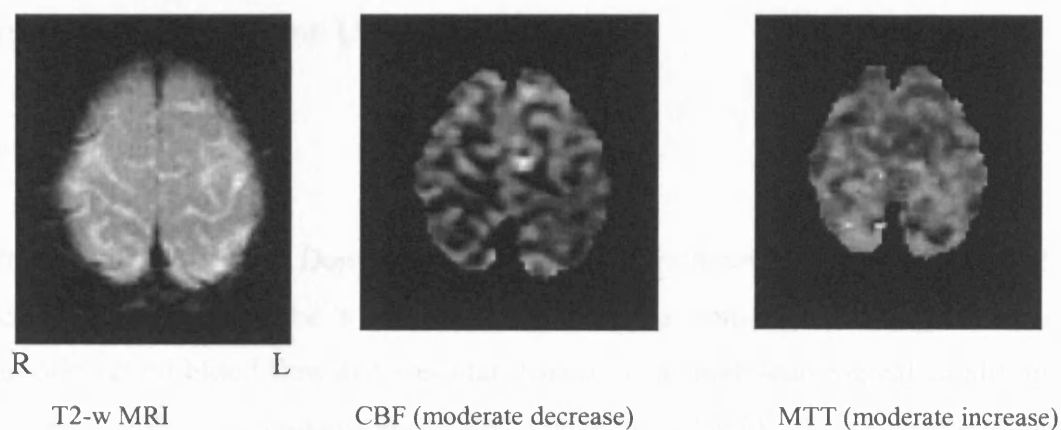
Perfusion MRI (DSC-MRI) in a patient with sickle cell anaemia, posterior territory TIA (double vision) and headaches. TCD MCA velocities were > 200 cm/sec. Normal T2-weighted MRI; moderate decrease in cerebral blood flow (CBF) or (- -), moderate increase in the mean transit time (MTT) or (+ +) in frontal parietal areas bilaterally. R: right; L: left. Cerebral blood volume (CBV) maps are similar to CBF.
